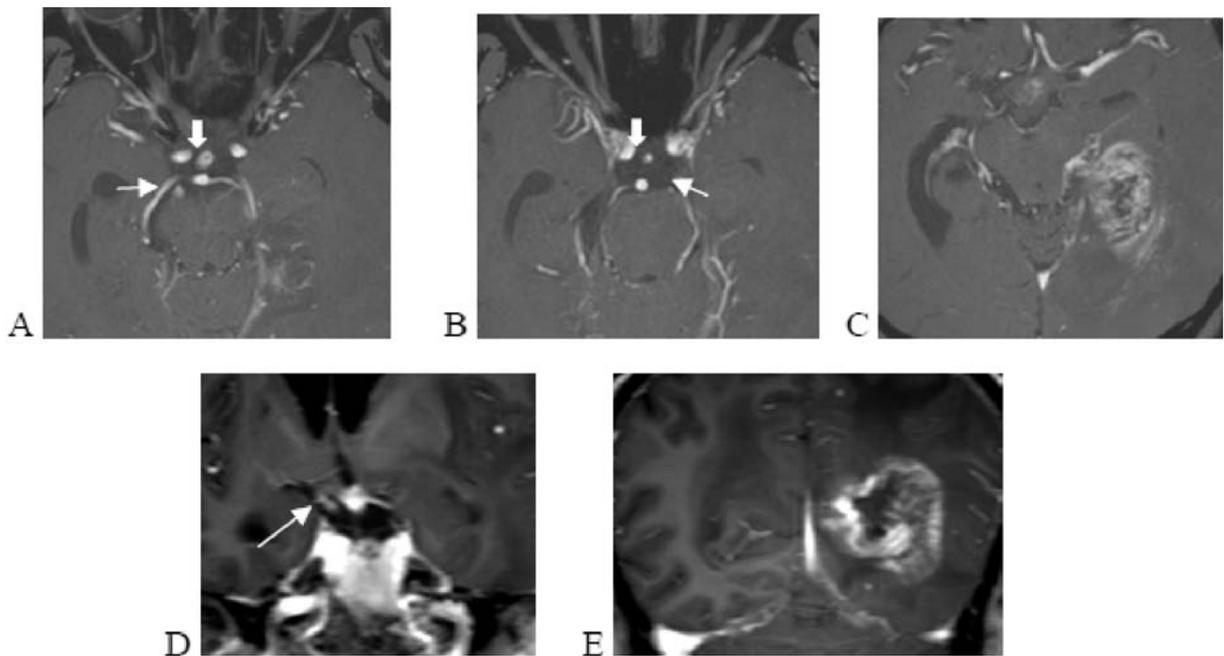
Case 5: glioblastoma with leptomenigeal seeding: A 58-year-old male, known case of glioblastoma status post surgery and chemoradiation. He presented with diplopia and was found to have right oculomotor nerve palsy on physical examination. MRI of the brain axial (A, B, and C) and coronal (D and E) post gadolinium T1WI shows abnormally thickened enhancement along bilateral CN III (A, B and D, white arrow), and pituitary infundibulum (A and B, white thick arrow), suggested leptomenigeal seeding. There is irregular rim enhancing lobulated lesion or residual / recurrent glioblastoma with area of necrosis and post treatment change involved left occipito-parietal lobe and left choroid plexus (C and E).
